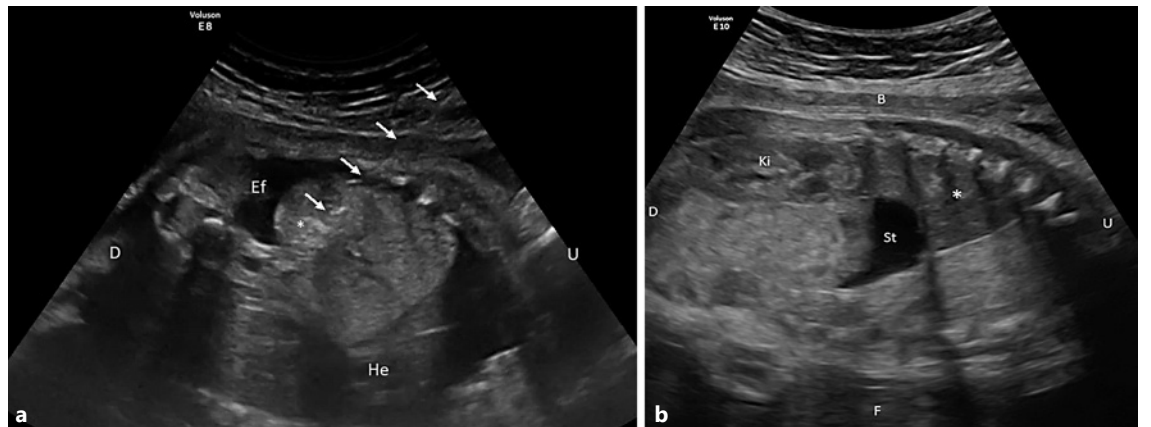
a Perioperative ultrasound, frontal view: (→) visualization of the 17-gauge needle adjacent to the vessel. (*) BPS. b Postoperative ultrasound exam, parasagittal view: The sequestration (*) becomes hypoechoic and decreases in size. Complete regression of pleural effusion. St, stomach; Ki, kidney; U, up; D, down; BPS, bronchopulmonary sequestration; He, heart, Ef, effusion; U, up, D, down.
